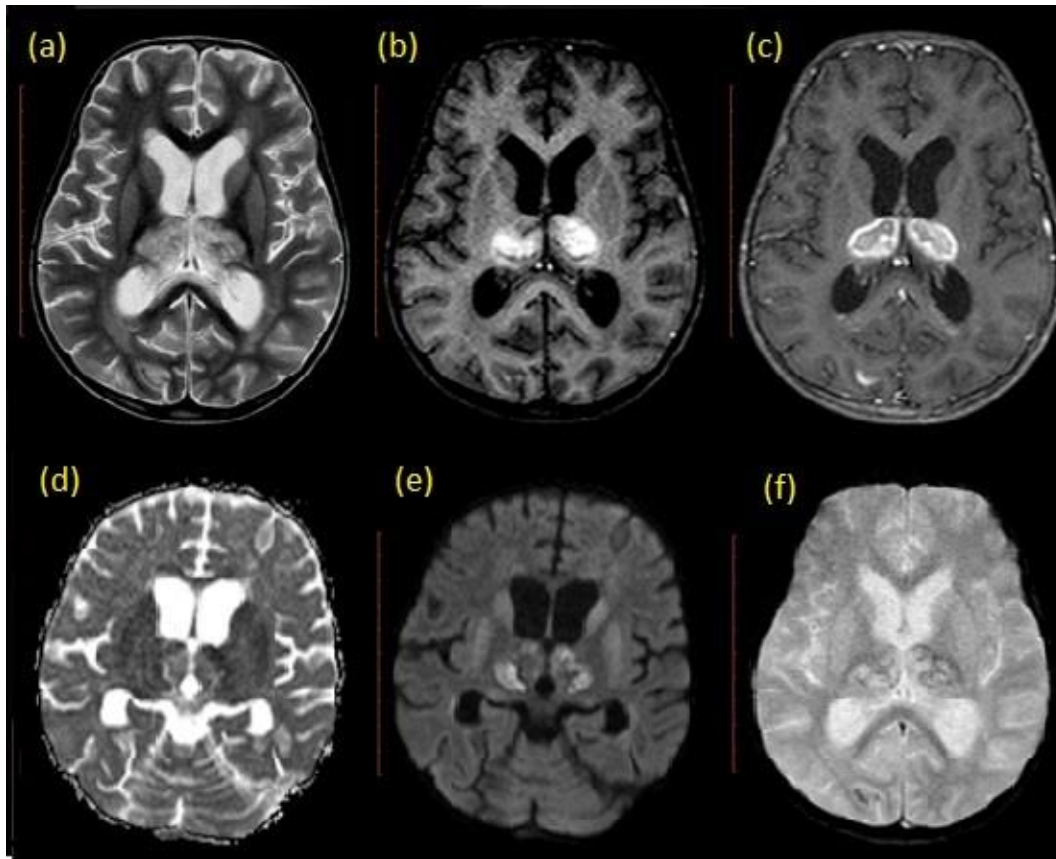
Japanese B Encephalitis: Axial T2/FLAIR images show hyperintense signal in bilateral thalamus, basal ganglia and midbrain (a,b), contrast enhancement in bilateral thalamus in axial T1 postcontrast image (c), restrictive diffusion in axial DWI/ADC images (d,e), foci of blooming in bilateral thalamus in FFE image (f).
